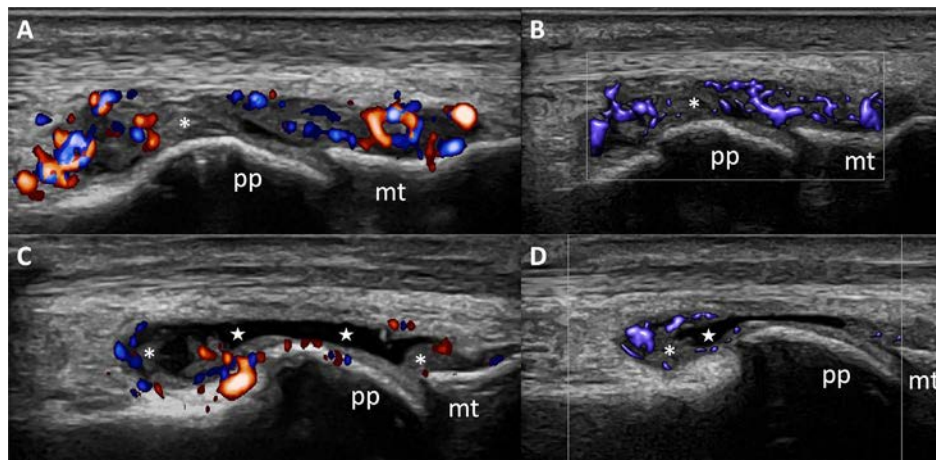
Long-axis ultrasound images of the right (A, B) and left (C, D) 1st metatarsophalangeal joints demonstrate synovitis (asterisks) and marked effusion (stars). Power Doppler (A, C) and superb microvascular imaging (B, D) findings are observed to be worse on the right side. pp., proximal phalanx; mt, metatarsal bone.
